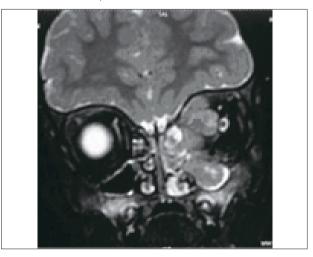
MRI coronal spin echo T2 Fat Sat weighted images: The sequences reveal an orbital and left maxillary sinus extension of tumor
